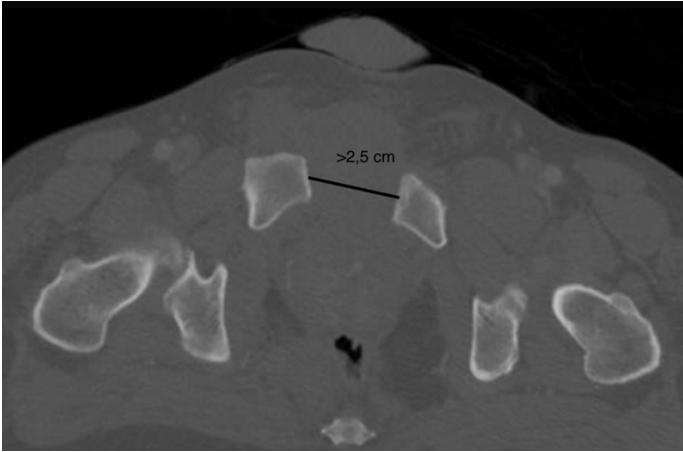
Axial CT images show a pubic diastasis  $>2.5$  cm.
